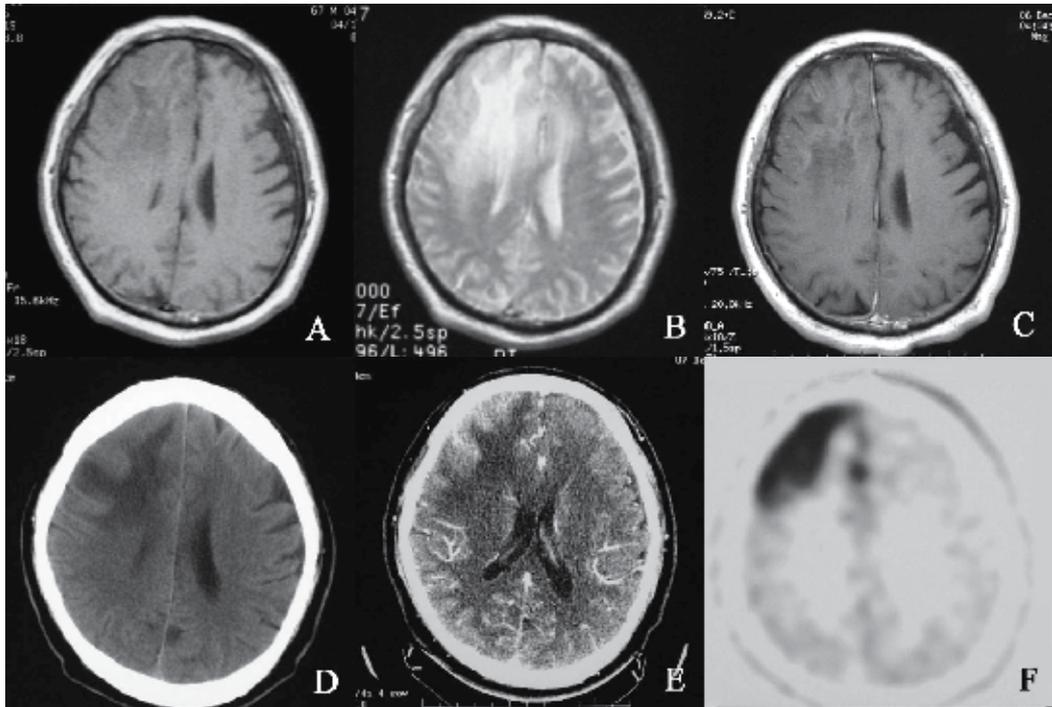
A 65-year-old man with a diffuse lesion in the right frontal lobe. A-C: T1-weighted magnetic resonance images (A, B), and with contrast medium (C), showing a mass with unclear margins in the right frontal lobe, appearing as slightly hypointense on the T1-weighted and hyperintense on the T2-weighted images without obvious enhancement. D, E: Computed tomography scan (D) and with contrast medium (E), showing the irregular lesion as uniform density with an unclear border and slight enhancement deep within the right frontal lobe cortex. F: ^{11}C -methionine positron emission tomography scan, showing an irregular high uptake area in and below the right frontal lobe cortex with a clear margin.
